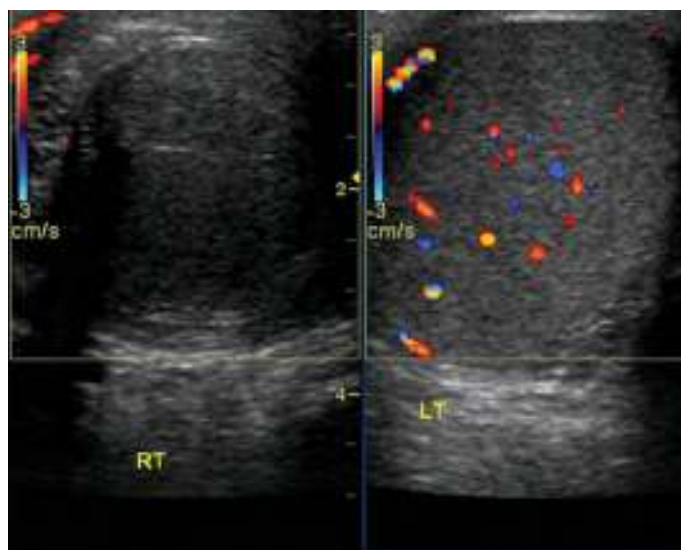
Color Doppler US image showing no flow in the right testicle (left side of picture) and normal flow in the left testicle (right side of picture). (Photo used with permission from www.iame.com.)
